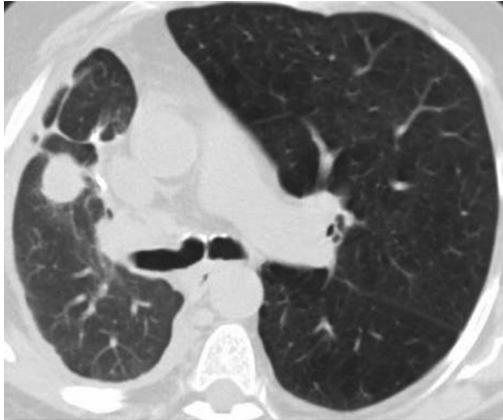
Computed tomogram shows a 2.7-mm nodule in the anterior right mid-lung zone, and pleural effusion and thickening.
